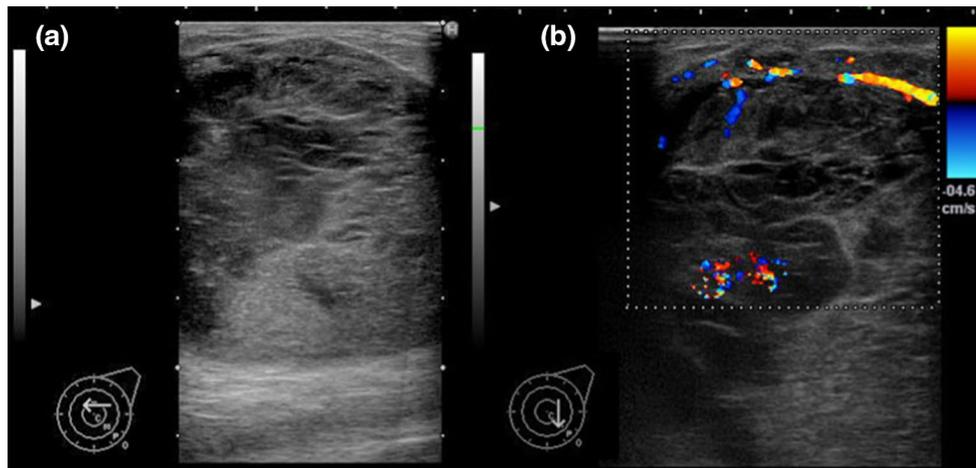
Ultrasonography showing a mainly well-circumscribed, hypoechoic tumor (a). Internal echoing was heterogeneous and hypervascular (b)
